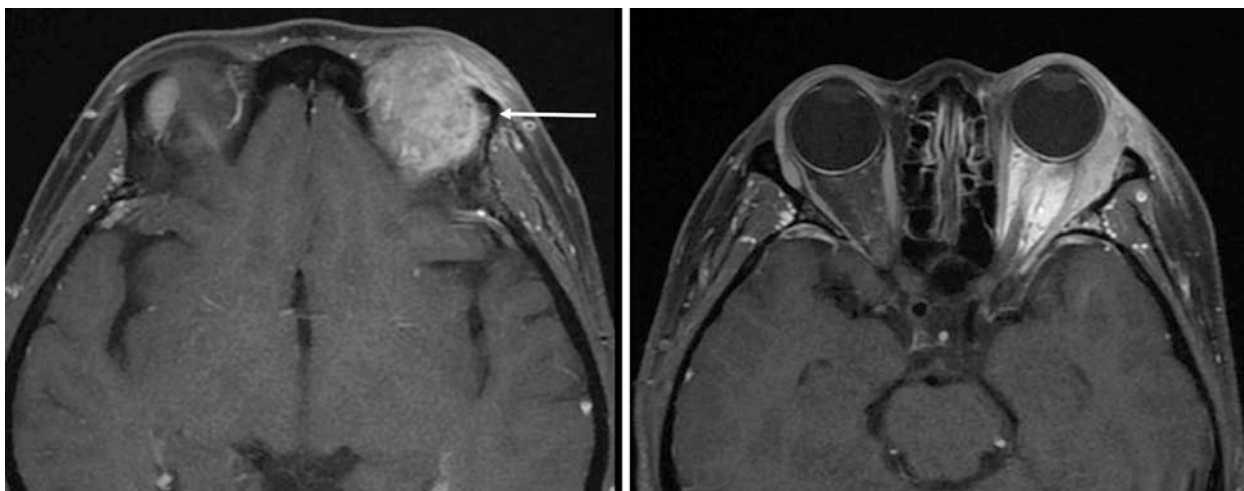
T1w post-contrast axial MR images. Left: showing soft tissue mass occupying the superior aspect of the left orbit with invasion of the mass into the lateral orbital wall (white arrow). Right: showing the mass abutting the globe and the lateral rectus. Note the left proptosis
